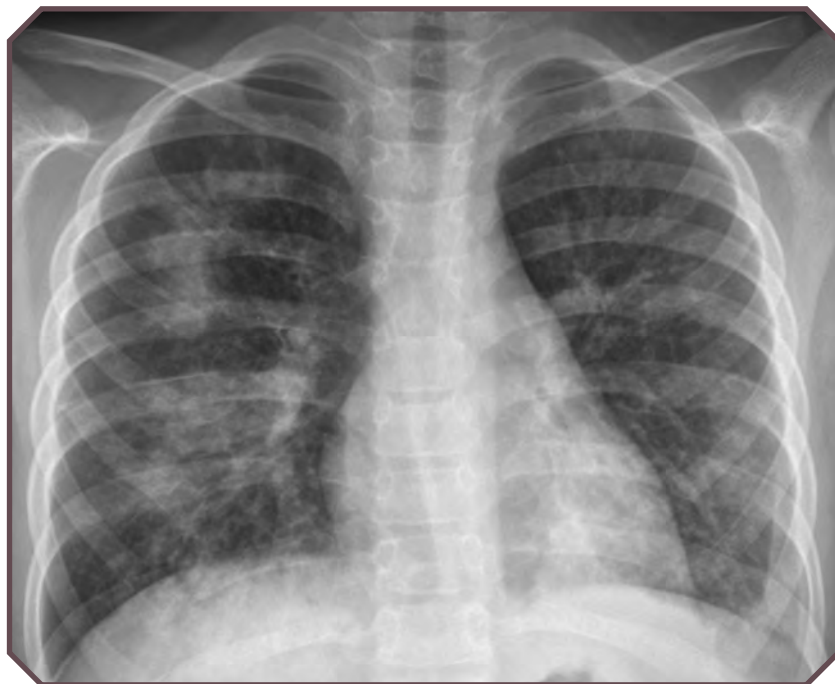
Mycoplasma pneumoniae* in a previously healthy 9-year-old boy. Frontal chest radiograph shows nonspecific bilateral upper and lower lobe patchy opacities.
